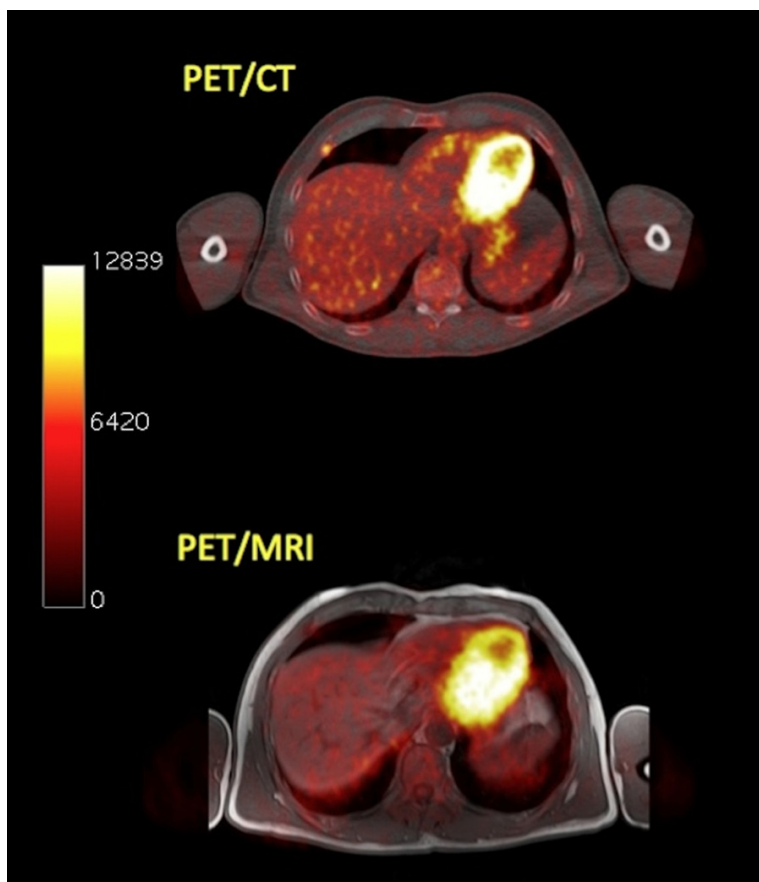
Transaxial PET/CT (upper row) and PET/MRI (lower row) images of a pre-treated stage III MM patient. On PET/CT a myeloma-suspicious lesion in the right 5th rib ventrally is depicted. PET/MRI shows no pathologically enhanced ¹⁸F-FDG uptake. Same patient as in Figure 5.
